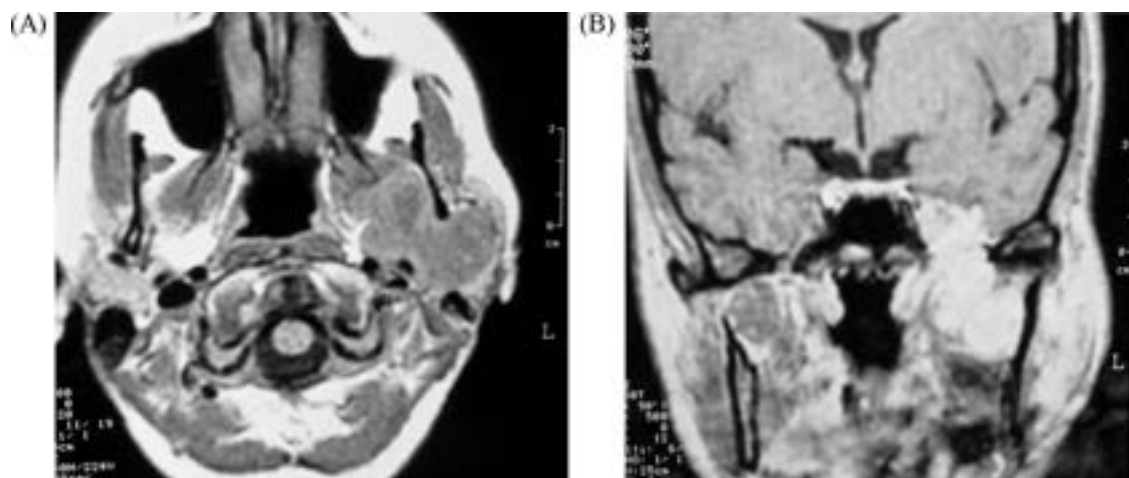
(A) Preoperative axial T1 MRI showing a schwannoma of the V3 cranial nerve involving the upper PPS. (B) Preoperative coronal T1 MRI with gadolinium contrast showing the involvement of the foramen ovale.
